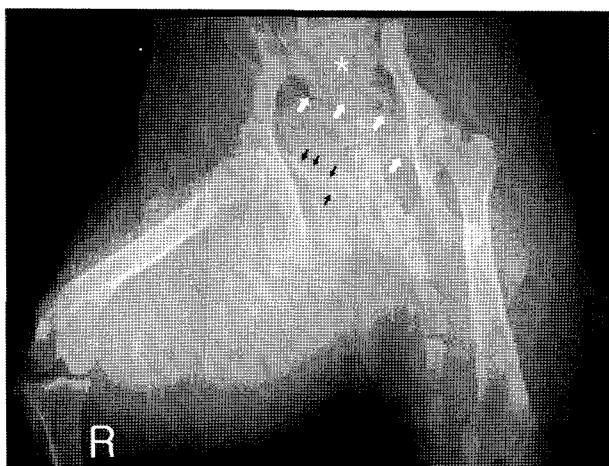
On radiograph, a mass is seen with increased soft tissue density in the posterior region of the femur. The pubis shows an irregular radiographic density and margin (black arrows). The rectum (*) is displaced by the mass (white arrows) in the pelvic cavity.
